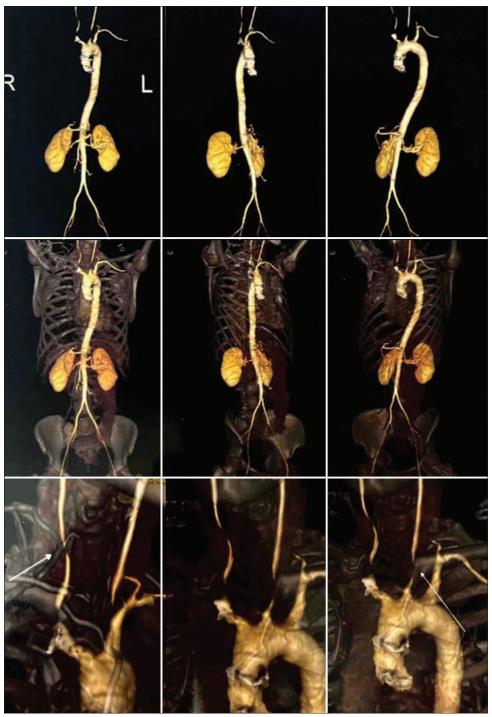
Computed tomography aortogram showing normal aorta and bilateral narrowing of common carotid artery lumen (bottom row arrow)
